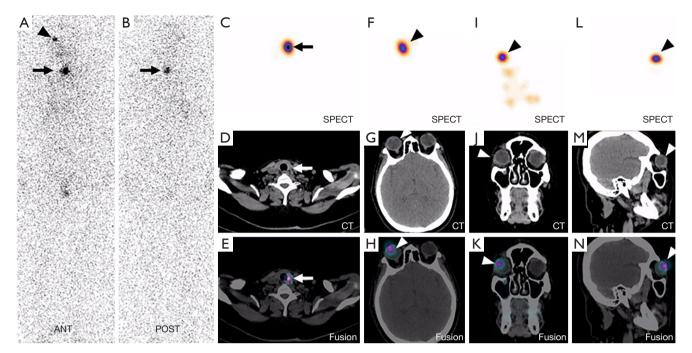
The post-therapeutic ¹³¹I WBS and SPECT/CT findings. ¹³¹I WBS showed two foci of ¹³¹I (A, anterior view, arrow and arrowhead; B, arrow and posterior view). SPECT/CT was performed and revealed that one lesion was in the thyroid bed (arrows) and represented residual thyroid tissue (C-E), and the other was in the right eye (arrowheads) (F-H, axial; I-K, coronal; and L-N, sagittal). WBS, whole-body scan; SPECT, single-photon emission computed tomography; CT, computed tomography.
